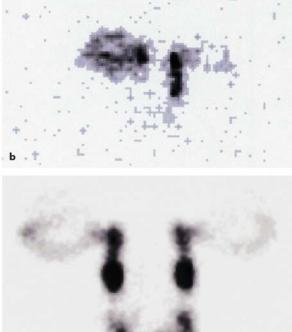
Nuclear lacrimal scintigraphy. a Set-up for nuclear lacrimal scan. The patients sits upright with the head fixed in front of the pinhole collimator of a gamma camera. Serial images are taken as the tracer passes through the system. b Patients with right-sided tearing and patency to syringing and nasolacrimal duct stenosis on dacryocystogram. Scan after 10 min. c Normal scintigraphy. d Scan after 20 min demonstrates significant decreased flow on the right and normal flow on the left. (From [14])
